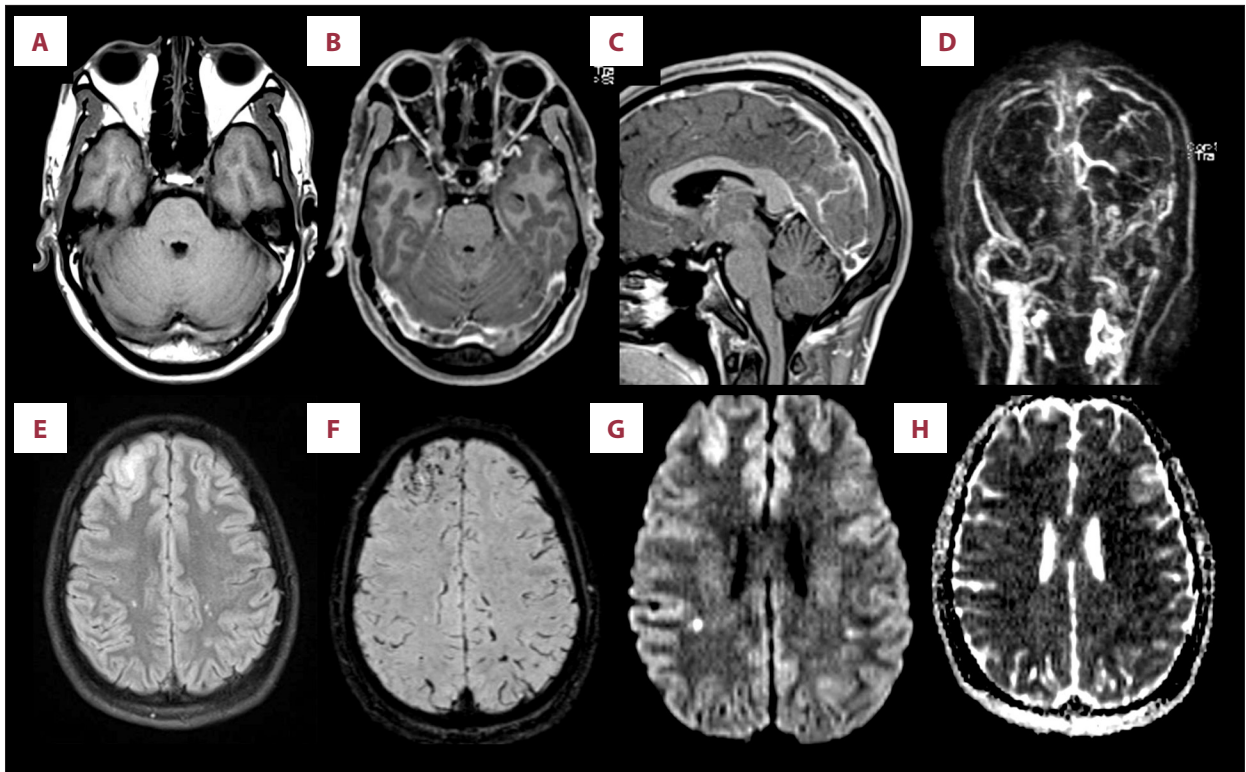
MRI brain including contrast-enhanced MR venography. (A) Axial T1-weighted pre-contrast image shows signal in bilateral transverse sinuses isointense to grey matter. (B) Axial and (C) sagittal T1-weighted post-contrast images confirm filling defects within bilateral transverse sinuses, superior sagittal sinus, and straight sinus. (D) Coronal and (H) sagittal MIP images from MR venography demonstrate extensive thrombosis of the dural venous sinuses extending into the left internal jugular vein. (E) FLAIR image shows small area of cortical and subcortical edema in the right frontal lobe, with presence of microhemorrhages at this site on SWI (F). (G) DWI images show small foci of diffusion restriction within the temporoparietal white matter bilaterally, compatible with acute lacunar infarcts.
